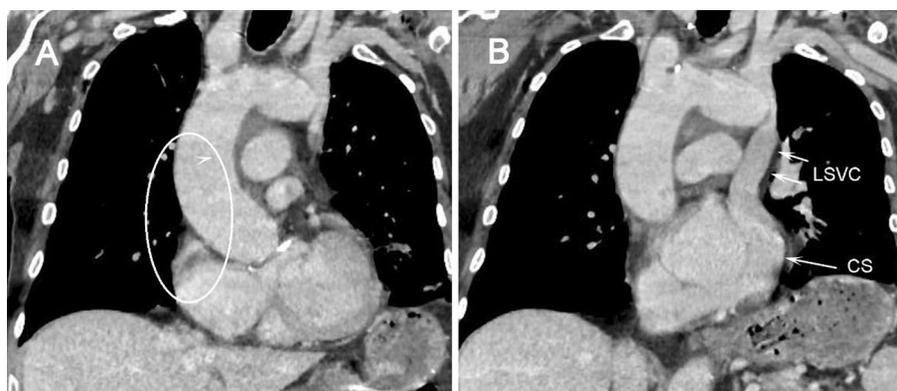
Male, 63 years old; a computed tomography scan showing the layout of single persistent left superior vena cava (LSVC) with respect to other thoracic structures and organs; A. A frontal cross section showing a lack of right superior vena cava in its typical location (oval); B. A reconstruction adjusted to visualise LSVC drainage into the right atrium via the coronary sinus (CS).
